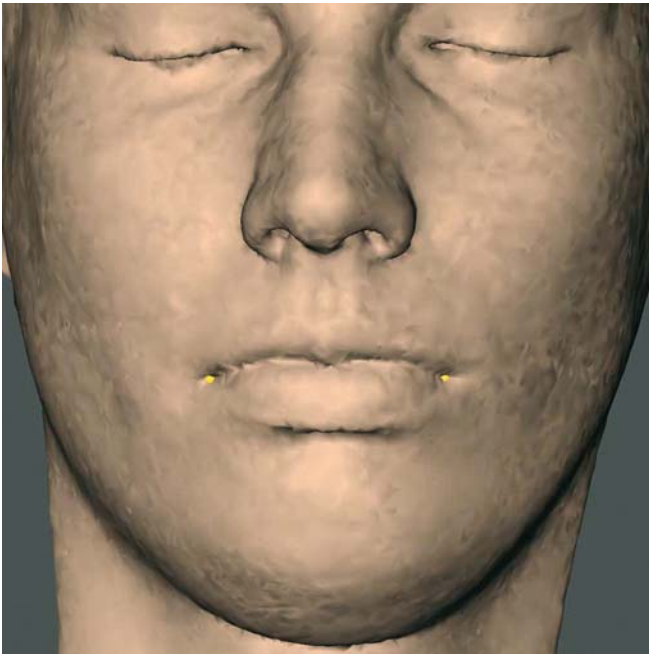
Cheilion_r and cheilion_l. Frontal view (3-D CT, patient K.C.)
